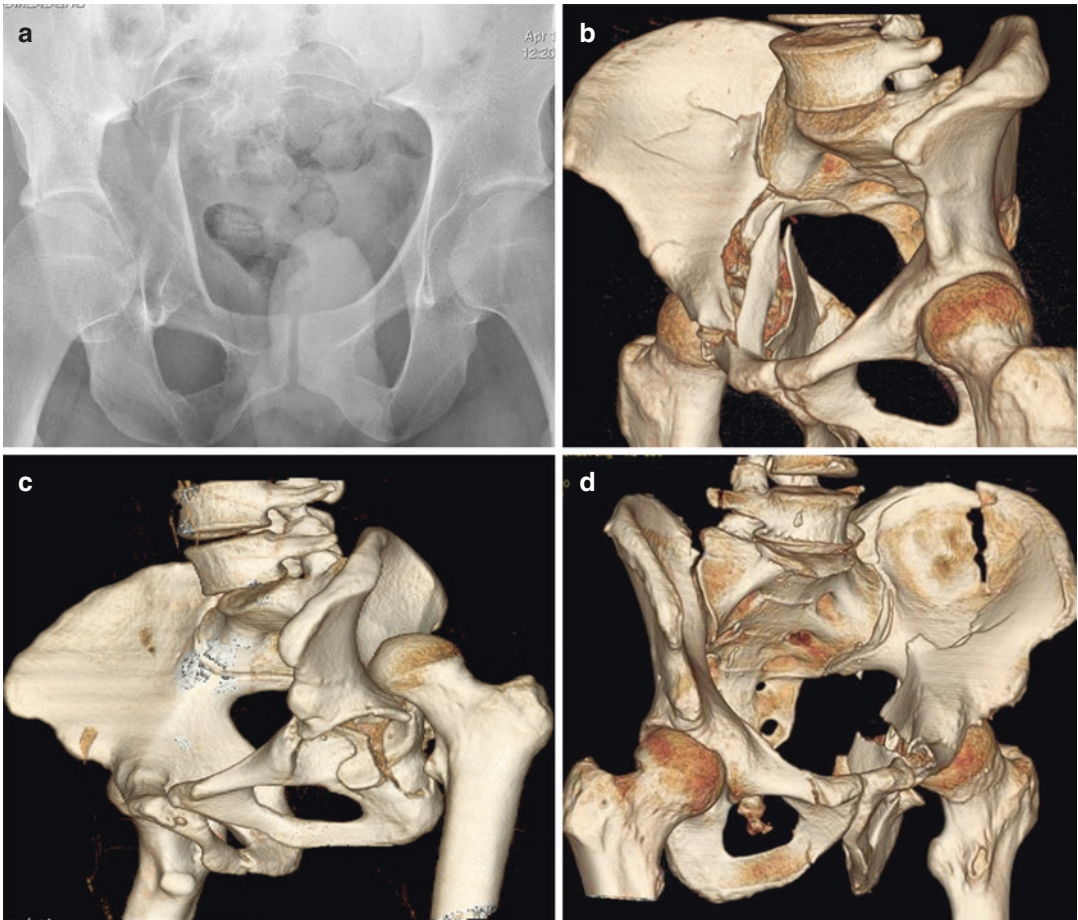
(a–d) (a) X-ray AP projection: complex acetabular fracture; (b) CT 3D (VR) reconstructions show the involvement of the medial wall of the acetabulum; (c) CT 3D (VR) reconstruction iliac oblique view shows the posterior wall fracture associated with the posterior dislocation of the femoral head. (d) CT 3D (VR) reconstruction
